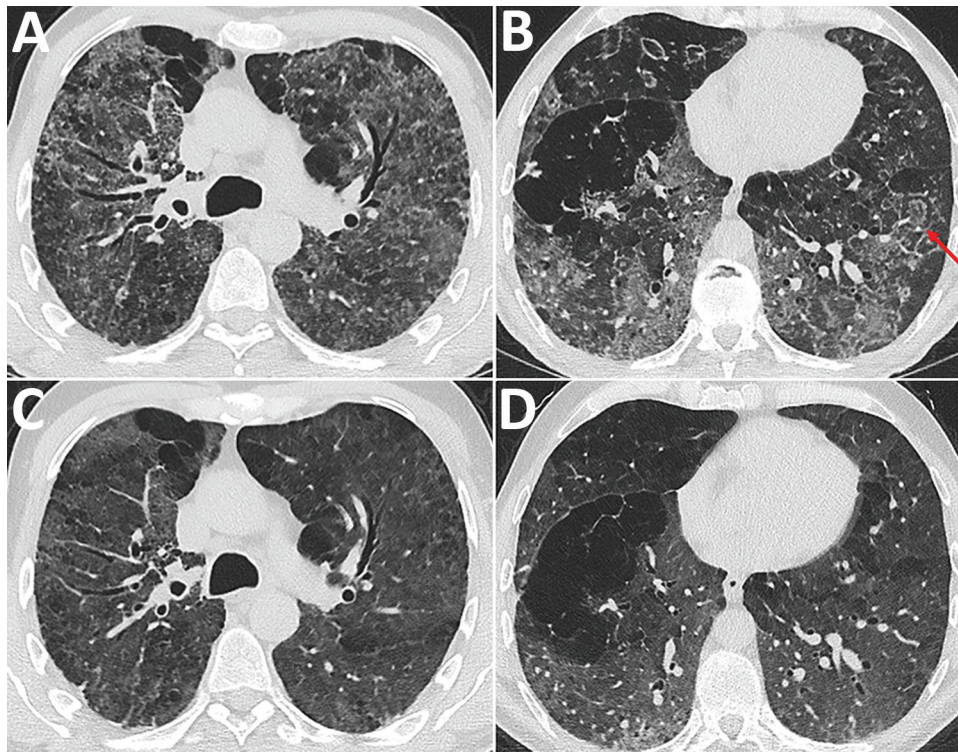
Chest computed tomography (CT) images at the level of the upper third and the lower third of the lung in a patient with pulmonary histoplasmosis, Switzerland. A, B) Initial CT shows diffuse reticulonodular pattern with ground glass opacifications, predominantly located in the upper two thirds of the lungs, and several areas with reverse halo signs (red arrows). C, D) Follow-up CT scan exhibited reduced ground-glass opacities and a regression of the micronodules. The reversed halos showed complete regression. CT, computed tomography.
